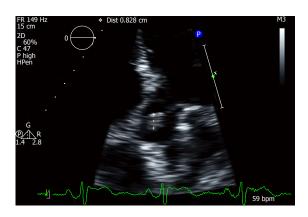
Transthoracic echocardiogram showing a cardiac papillary fibroelastoma on the aortic valve (marked).
